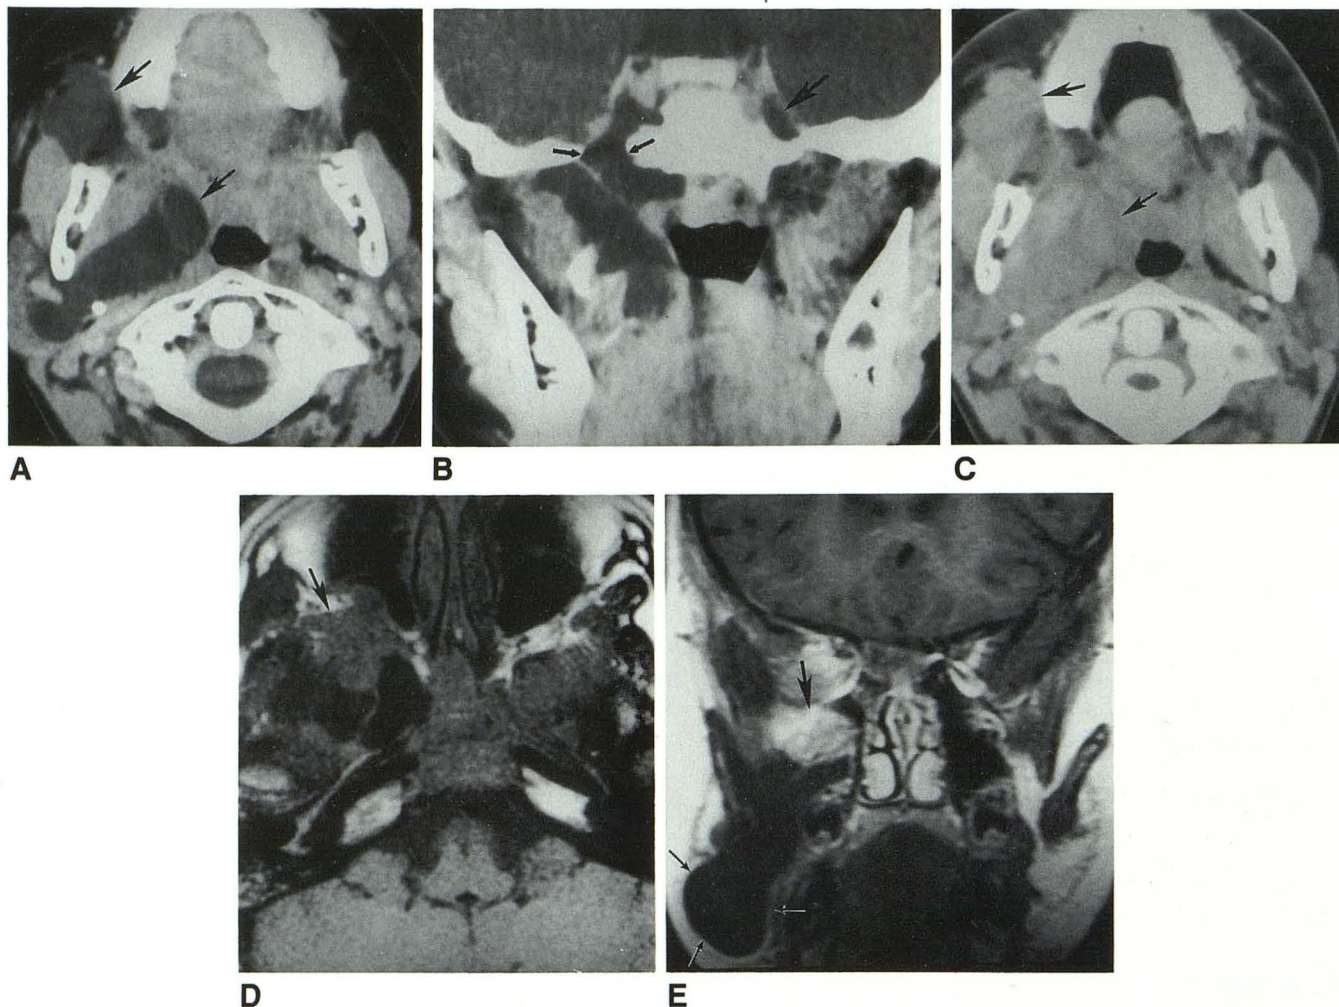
A, Axial CT following intravenous contrast shows a lobulated CSF density mass involving the right prestyloid and poststyloid parapharyngeal space, the masticator space, and the temporalis fossa (arrows).
